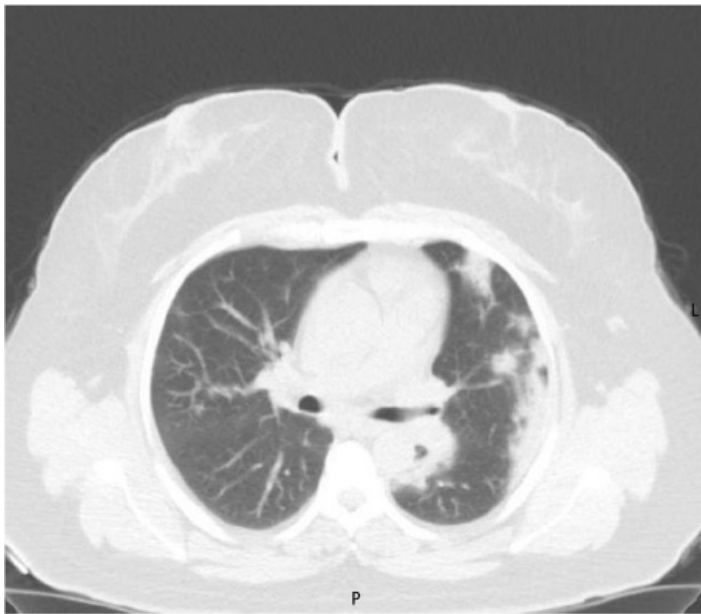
Chest CT, Multiple mottling and ground-glass opacity
